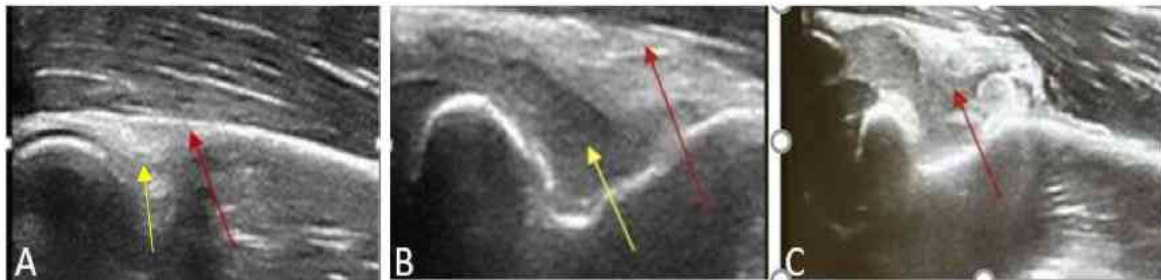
Sonographic signs of normal fat pad, elevated fat pad and lipohemarthros
